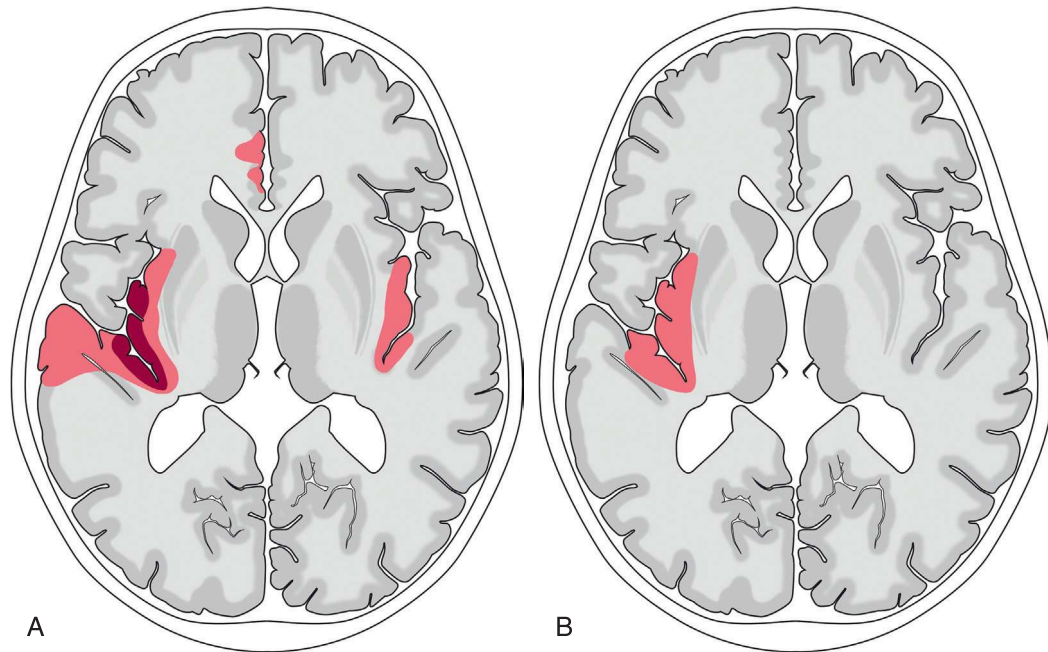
Typical MRI features of herpes simplex encephalitis. (A) On presentation there may be unilateral or bilateral asymmetric involvement of limbic system structures, including the temporal lobes, insulae, and cingulate gyri. Restricted diffusion, representing areas of necrosis, is a characteristic feature but not always present. Extensive FLAIR hyperintensity is typically seen. Areas of enhancement or hemorrhage are sometimes seen. (B) Follow-up imaging after several months shows parenchymal volume loss and some residual FLAIR hyperintensity in the regions most severely affected.
